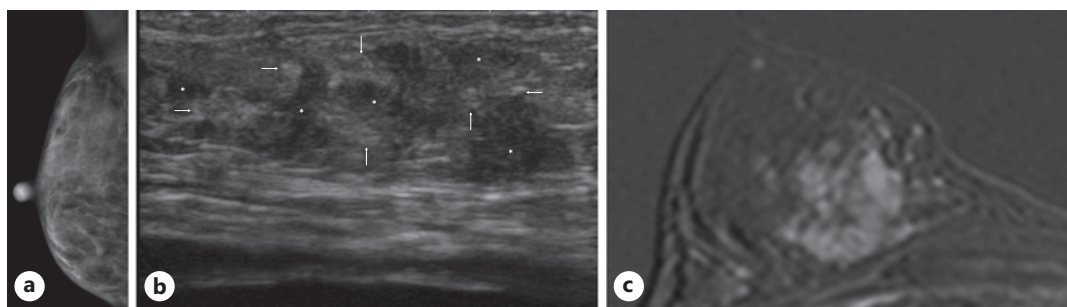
MMG, ultrasonography, and magnetic resonance images of the right breast. a MMG with a dense breast pattern showed neither tumors nor microcalcifications. b Ultrasonography showed focal hyper-echoes (arrows) and hypo-echoes (asterisks) without distinct tumor formation. c Magnetic resonance images showed multifocal lesions with persistent enhancement.
